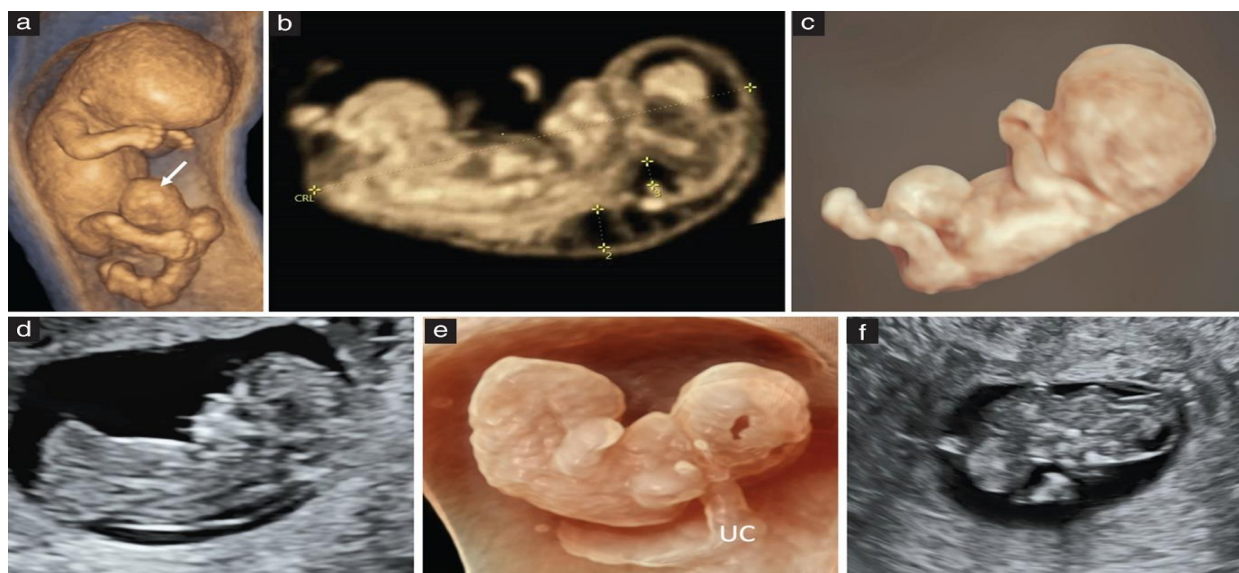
Sonographic detection of fetal abnormalities (Source:[10])
